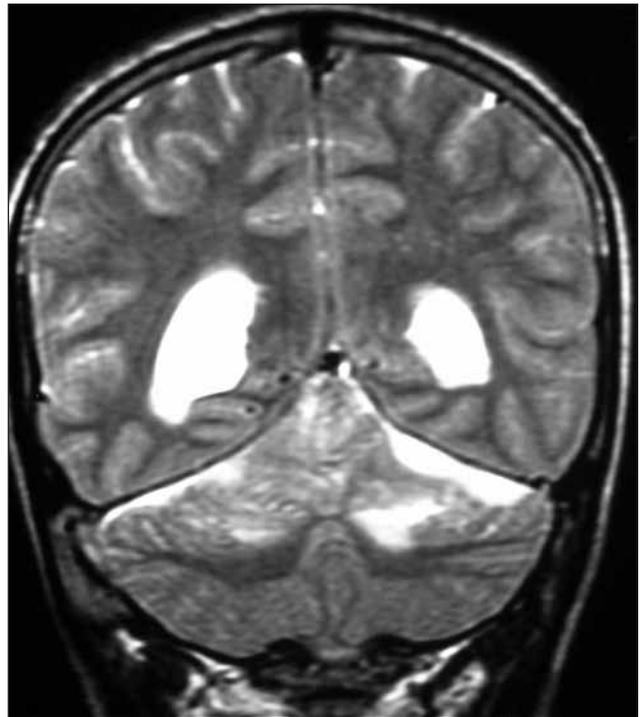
T2-weighted coronal image demonstrating subdural collection along the undersurface of the tentorium bilaterally.
